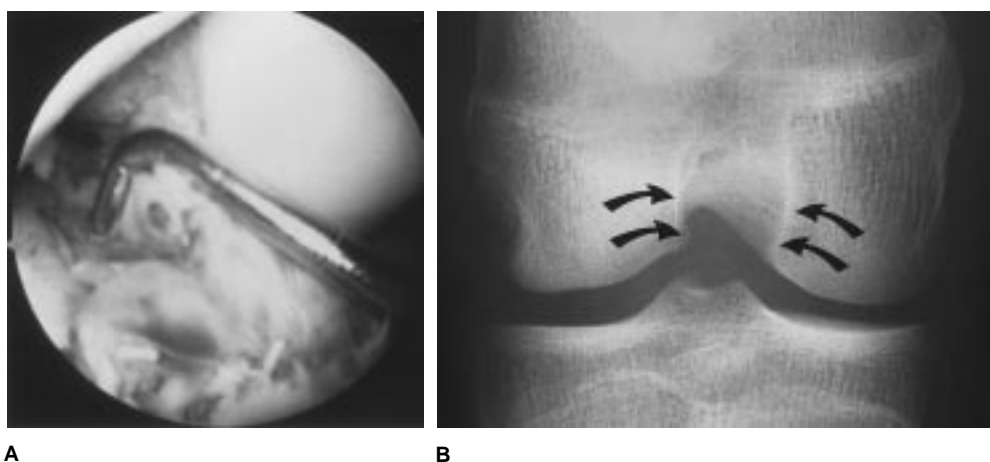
A, Arthroscopic view of a complete acute ACL tear in a premenarchal 13-year-old female basketball player with a very narrow femoral notch. B, Radiograph of same patient shows diminished notch configuration (arrows).
